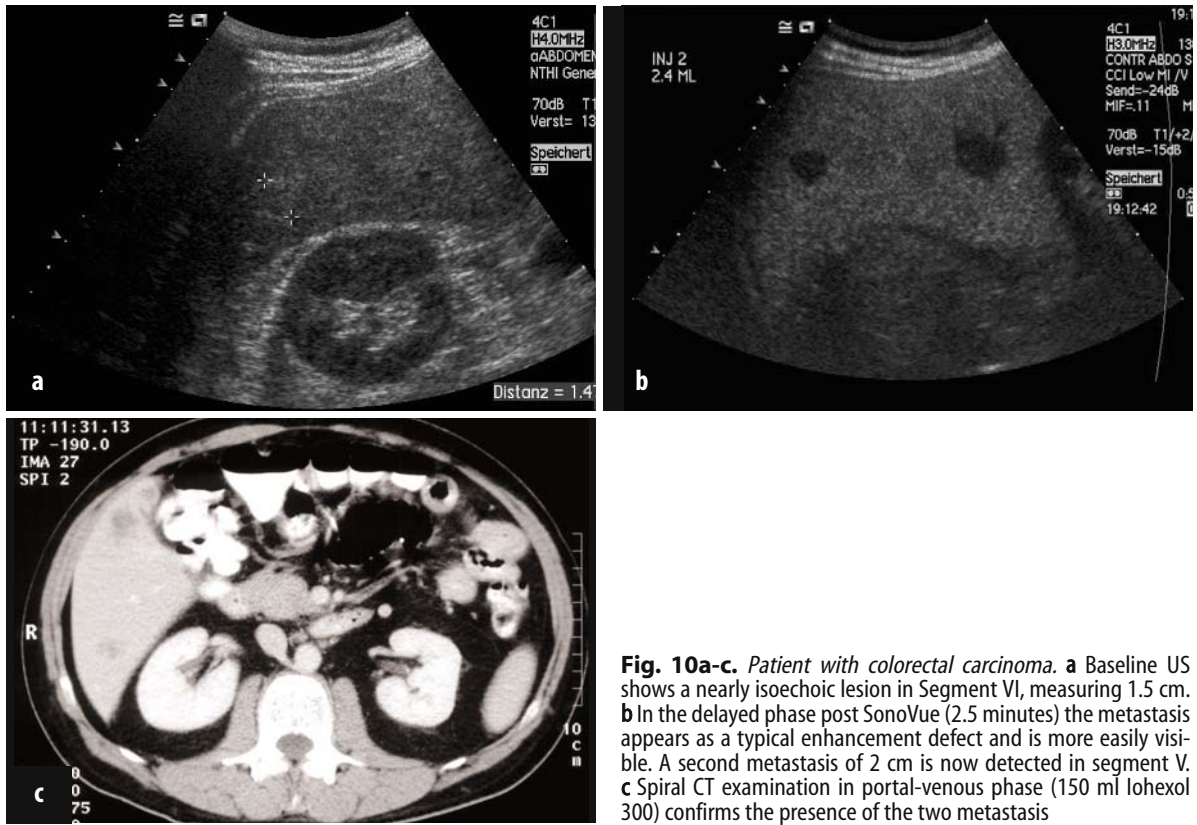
Patient with colorectal carcinoma. a Baseline US shows a nearly isoechoic lesion in Segment VI, measuring 1.5 cm. b In the delayed phase post SonoVue (2.5 minutes) the metastasis appears as a typical enhancement defect and is more easily visible. A second metastasis of 2 cm is now detected in segment V. c Spiral CT examination in portal-venous phase (150 ml Iohexol 300) confirms the presence of the two metastasis
